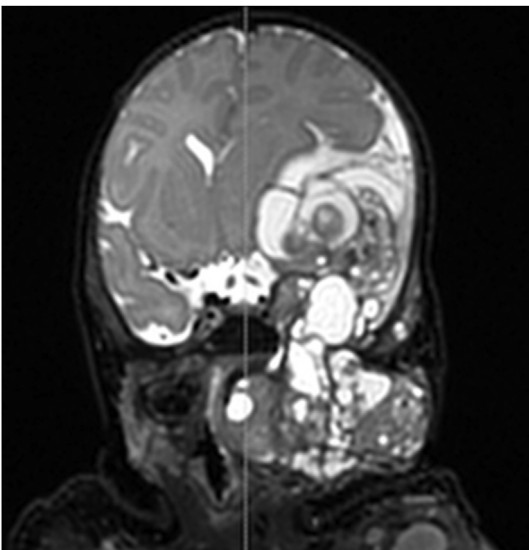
T2 weighted MRI - coronal image of the giant cranio-cervicofacial teratoma on day three of life.
